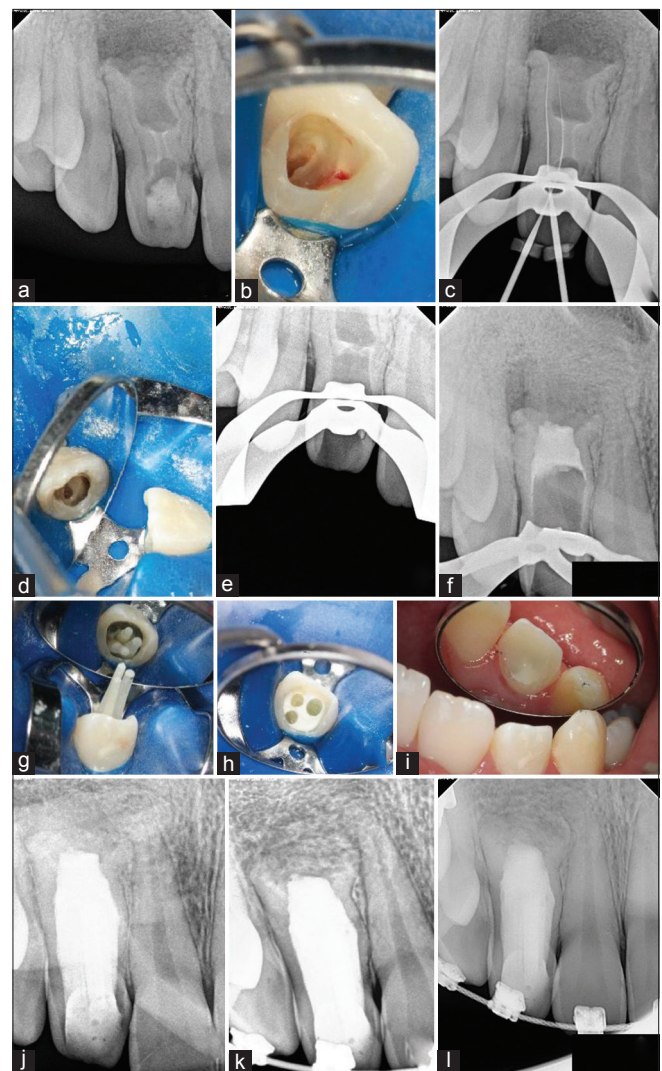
Treatment of tooth #7 (a) preoperative periapical radiograph, (b) photo of dens upon initial access showing vital pulp, (c) working length determination, (d) photo of ultrasonic removal of dens, (e) radiograph of dens removal, (f) radiographic confirmation of MTA placement in apical third, (g) fiber post photograph, (h) fiber post buildup photograph, (i) final restoration, (j) postoperative radiograph, (k) 12 months recall, (l) 24 month recall (Case performed by CA)
